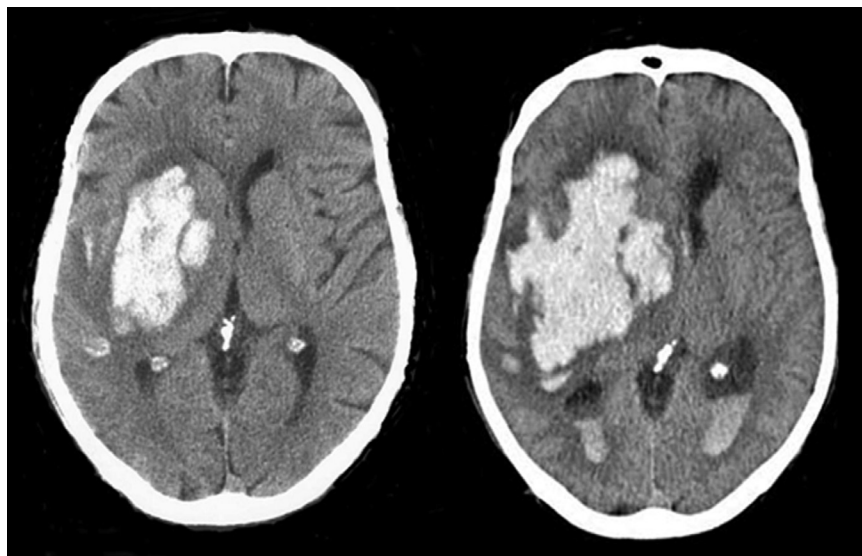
■ Example of hematoma enlargement. Computed tomography (CT) on left was obtained 2 hours after onset of left hemiparesis and shows right putaminal hemorrhage. CT on right was obtained 1 hour later when patient acutely deteriorated and shows expansion of hematoma, with intraventricular extension, midline shift, and enlarging ventricles.
